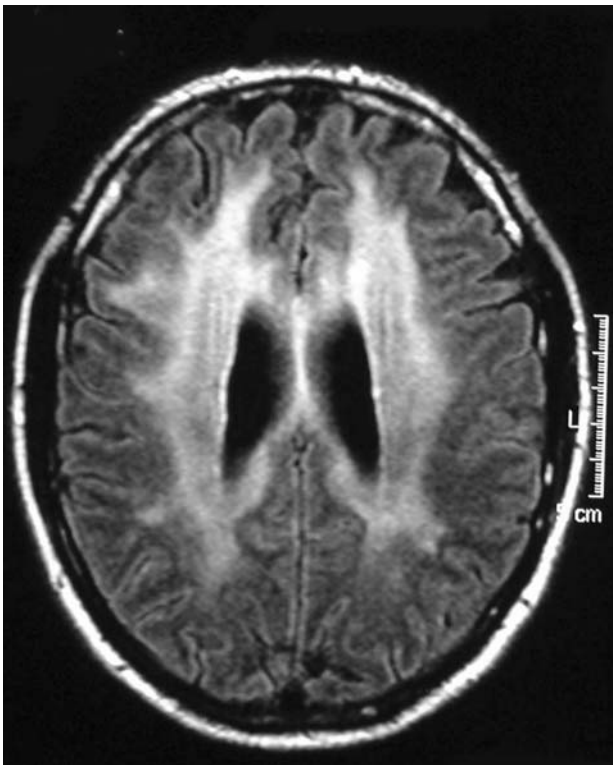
MRI of the brain, showing massive diffuse white matter hyperintensities as a sign of HIV associated encephalopathy.
